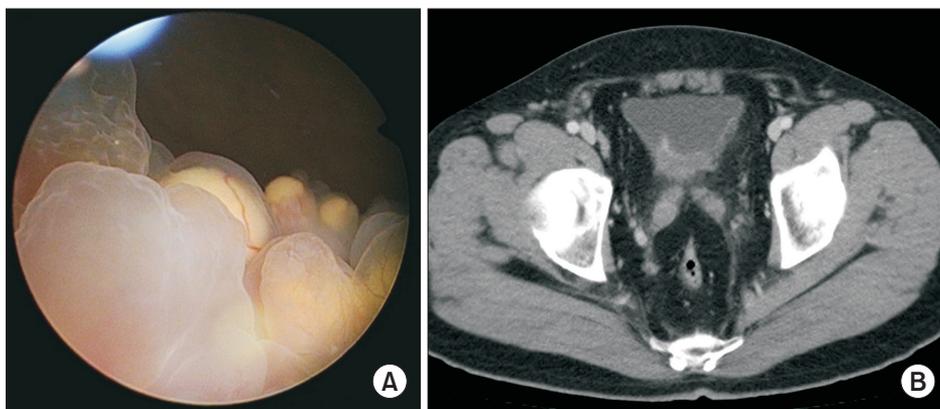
Typical findings of extensive-type cystitis glandularis on cystoscopy and computed tomography. (A) Cystoscopic view of pathologically confirmed cystitis glandularis. (B) Computed tomography showing a diffuse wall thickening of posterior wall.
